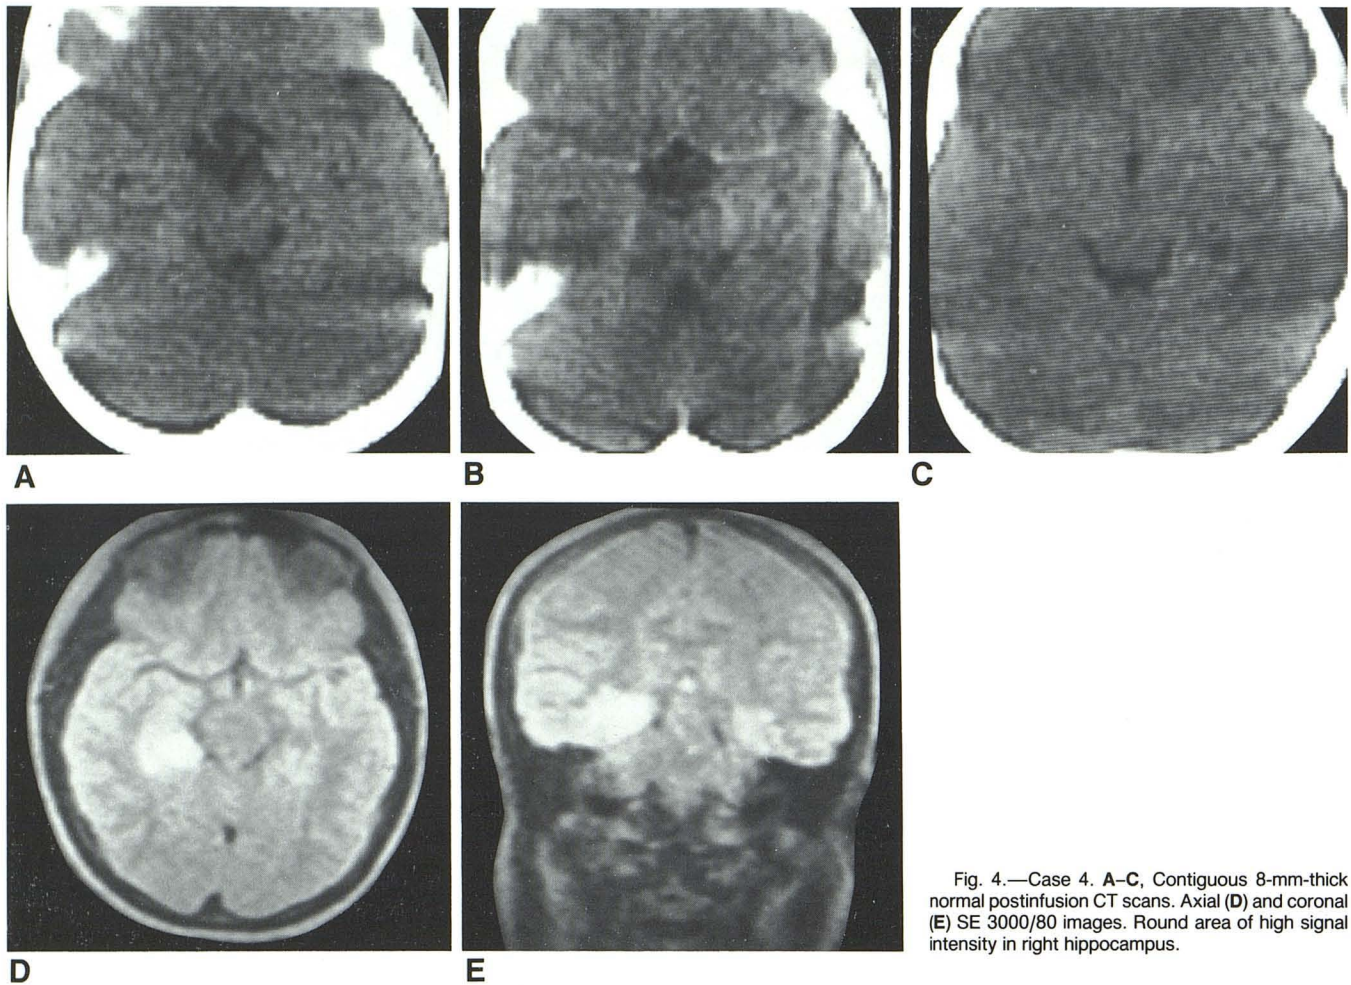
Case 4. A–C, Contiguous 8-mm-thick normal postinfusion CT scans. Axial (D) and coronal (E) SE 3000/80 images. Round area of high signal intensity in right hippocampus.
